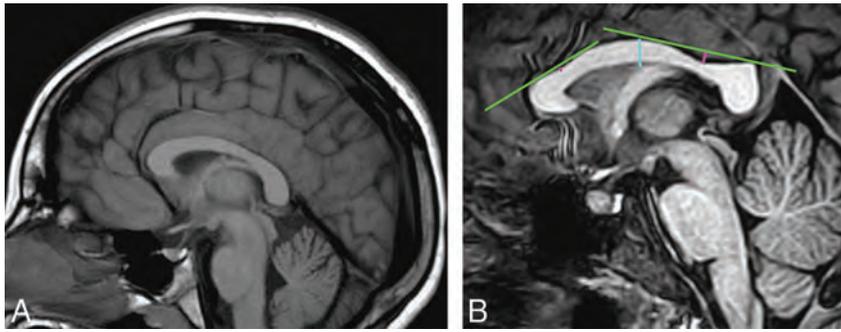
Midsagittal T1-weighted images. *A*, A normal corpus callosum with no notch. *B*, A corpus callosum with anterior and posterior notches measuring 1 and 3 mm in depth (pink lines), respectively. A “notch” was defined as a depression in the dorsal surface whose depth was at least 1 mm from a tangential green line to the surface of the CC. Notches are classified as either anterior or posterior on the basis of their relationship to the midcallosal body (blue line).
